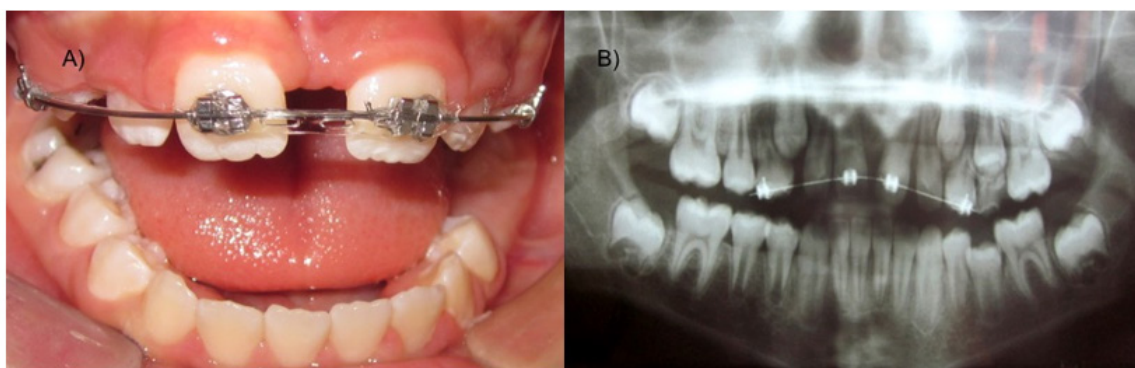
Progression of orthodontic treatment. (A) Intraoral photograph showing progressive closure of the maxillary midline diastema. (B) Panoramic radiograph demonstrating progressive space closure and an alteration in long axis of the maxillary central incisors during orthodontic treatment.
